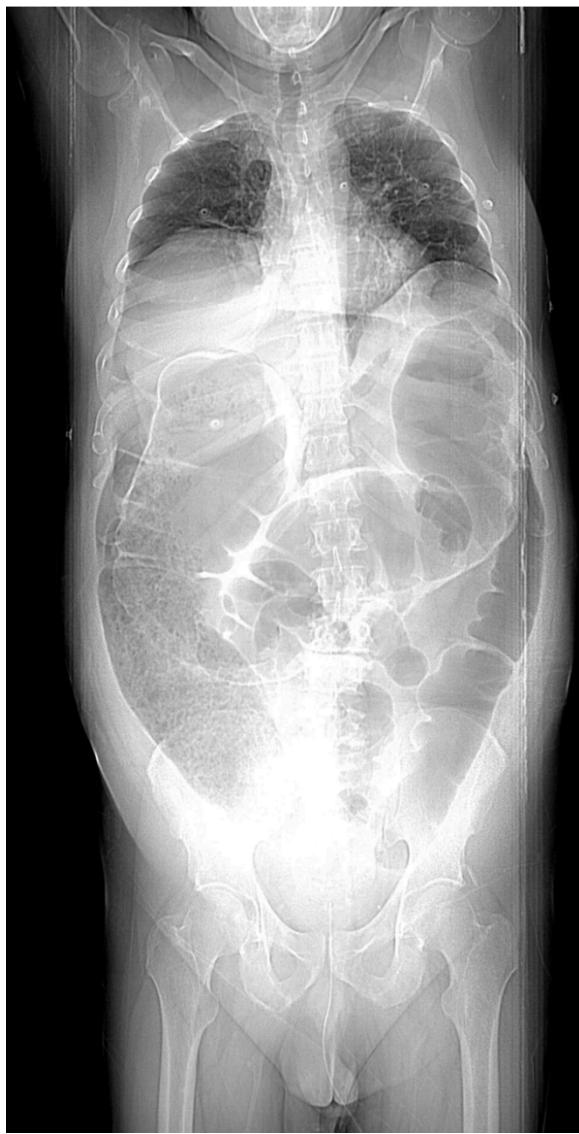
A high-resolution computed tomography of the abdomen showing free air in the abdominal cavity, axial view
